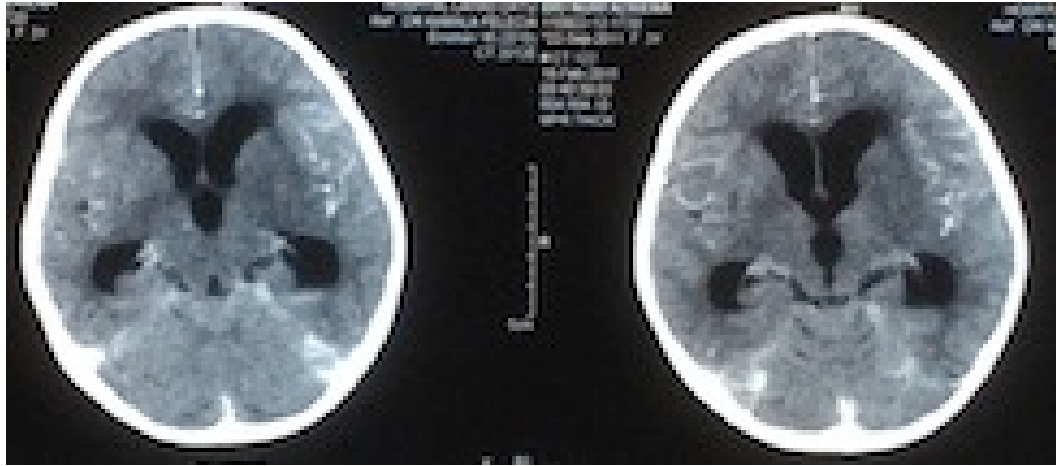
Axial view of plain CT brain showing diffuse subarachnoid haemorrhage with hydrocephalus.
